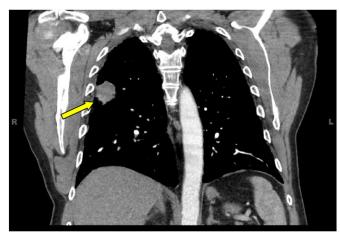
Chest CT scan shows a 3.0  $\times$  2.3  $\times$  2.5 cm RUL lung mass.
